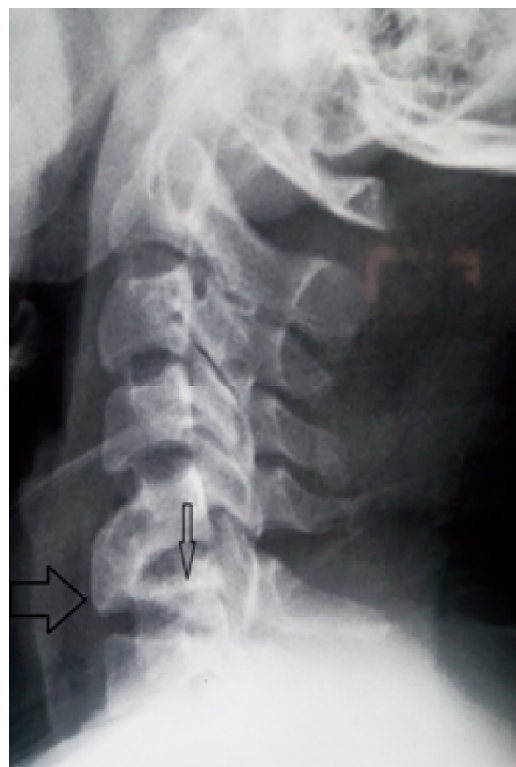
X-ray Cervical spine, lateral view showing collapse of sixth cervical vertebra (small arrow head) with arched large bony mass like an armored fused with fifth vertebra (horizontal large arrow)
